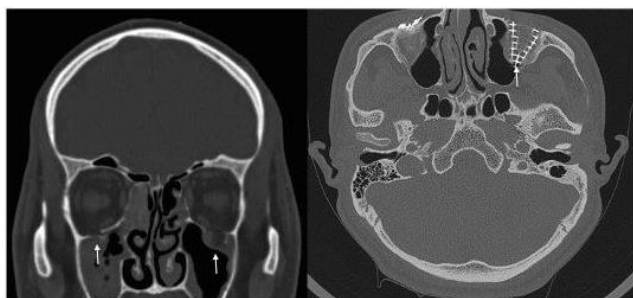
CT scan orbit in coronal view in patient 5 showing fracture floor of orbit both sides with incarceration of inferior rectus in coronal view both sides (white arrows, left panel). Right panel shows post-operative CT orbit, axial view with intact Titanium mesh, better visible on the left side (white arrow).
